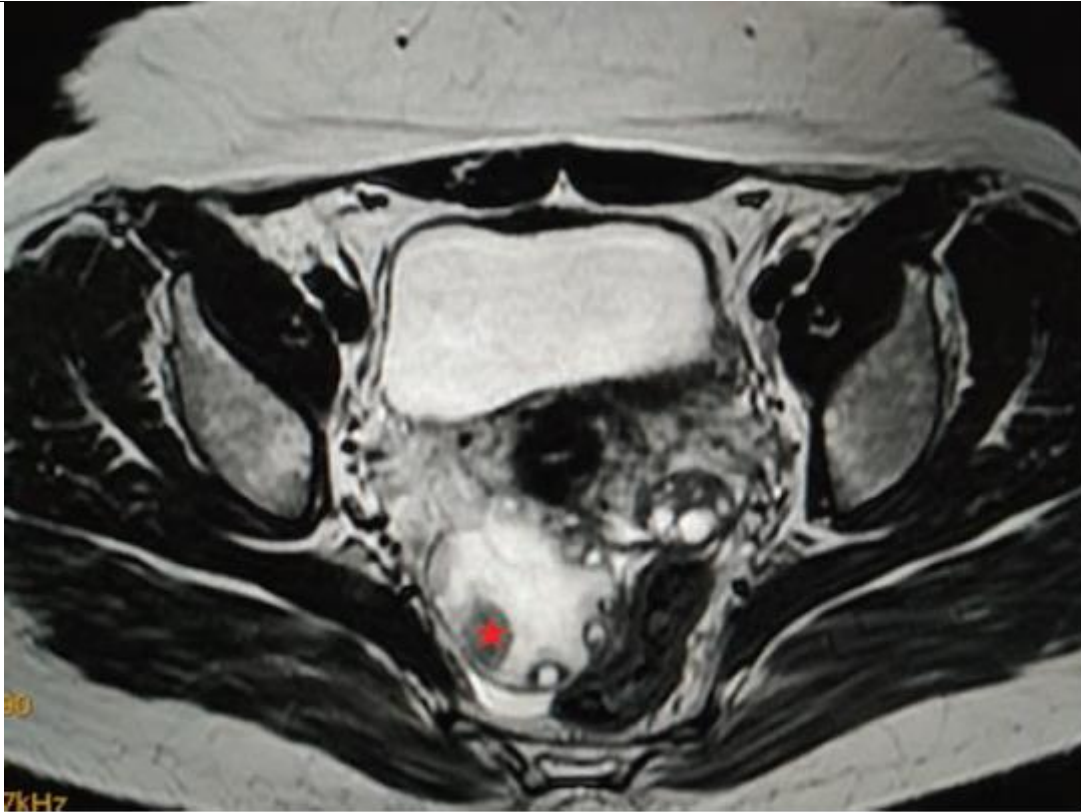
Axial T2-W MRI demonstrating bulky right ovary with well-defined hypointense solid lesion (star) and twisted ovarian pedicle features are of concern for neoplastic lesion of right ovary with probable torsion. MRI, magnetic resonance imaging.
